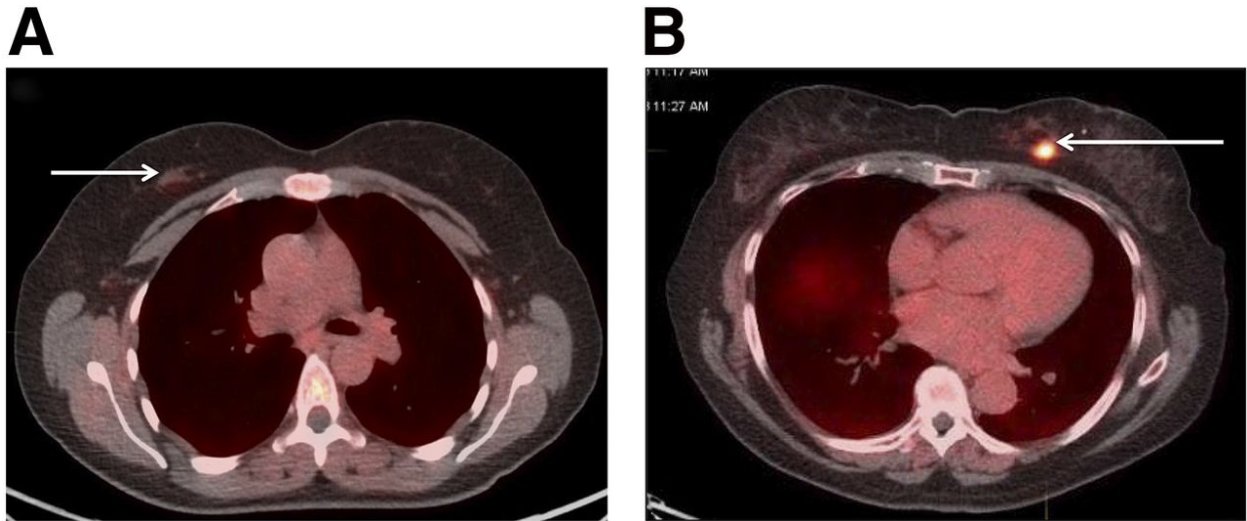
Axial fused FACBC-PET/CT images of (A) benign ductal hyperplasia (arrow) with SUV_{max} of 2.0 and (B) invasive ductal carcinoma (arrow) with SUV_{max} of 9.7. Reprinted with permission from Tade FI et al, J Nucl Med. 2016;57:1357-1363. © by the Society of Nuclear Medicine and Molecular Imaging, Inc. <http://jnm.snmjournals.org/content/57/9/1357.long>
